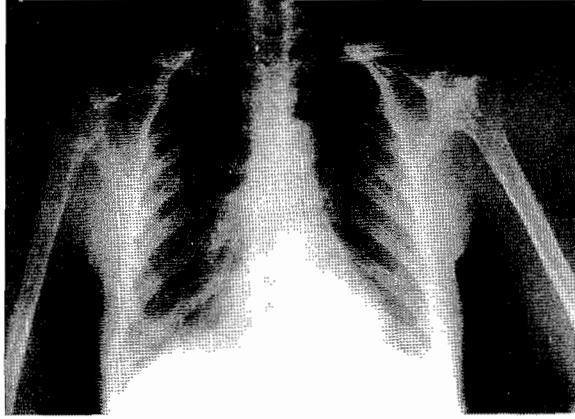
X-ray showing osteonecrosis of both humeral heads
